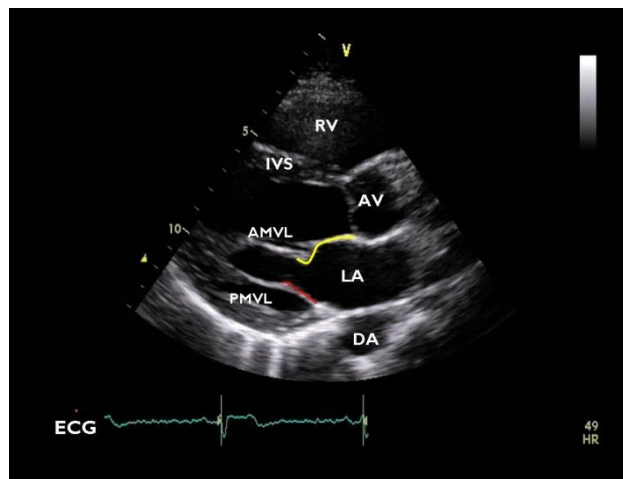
Two dimensional image (parasternal long axis view) with the anterior (yellow) and posterior (red) mitral valve leaflets highlighted. The frame is taken in late-diastole, with the valve leaflets clearly separated. AMVL; anterior mitral valve leaflet, PMVL; posterior mitral valve leaflet
